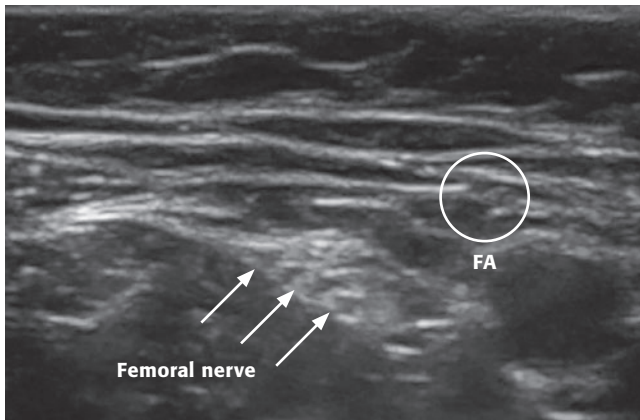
Ultrasound image of the femoral nerve. Abbreviation: FA, femoral artery.
